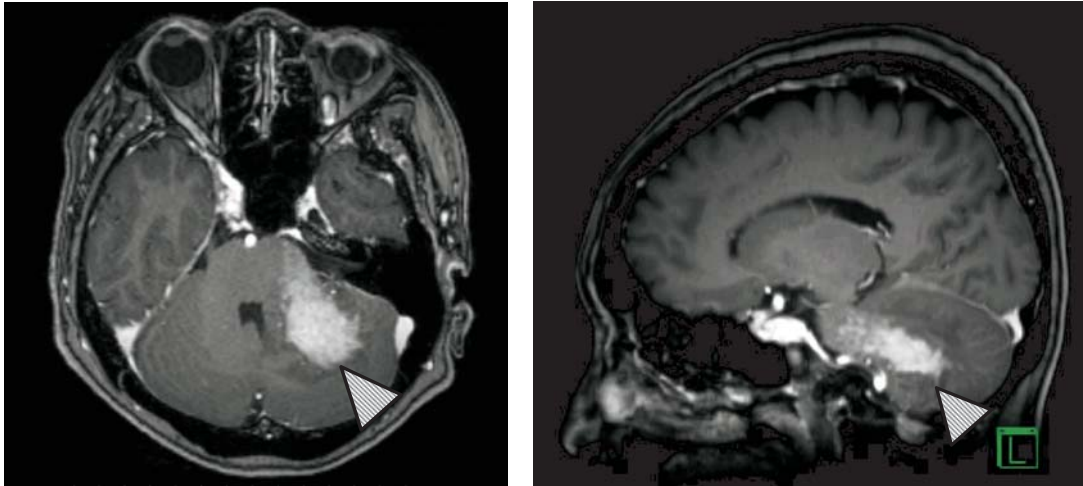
Brain magnetic resonance imaging (MRI) on admission. Contrast-enhanced MRI showed a 4-cm mass-like lesion extending from the left cerebellum to the pons (*arrowheads*). The distribution of the lesion was consistent with the patient's symptoms and we therefore judged it to be the culprit lesion. Cerebellum biopsy was performed because no malignant cells were detected in the cerebrospinal fluid by lumbar puncture.
